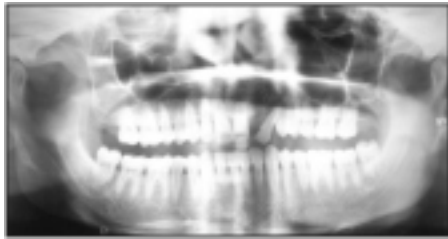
Orthopantomograph showing a well-defined multilocular lesion with radiolucent and radio-opaque foci.
